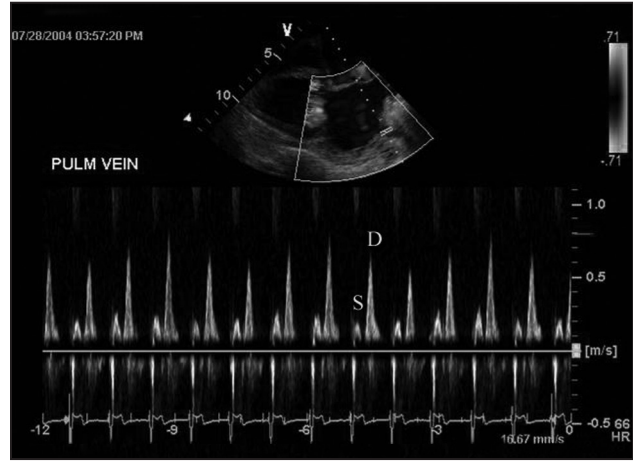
Right parasternal long-axis view demonstrating exaggerated respiratory variation of Doppler pulmonary vein flow suggestive of restrictive physiology of left ventricular filling. Notice the abrupt cessation of diastolic pulmonary vein flow most commonly associated with increased left ventricular filling pressure. S, systolic flow wave; D, diastolic flow wave.
